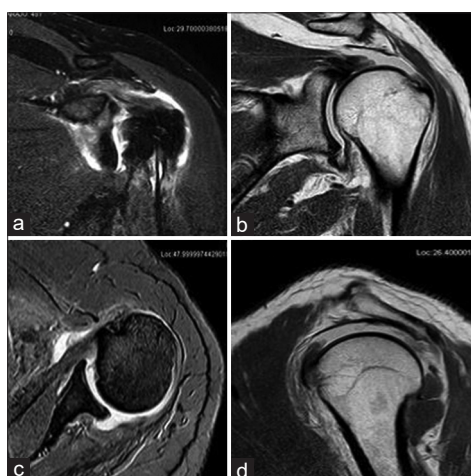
MRI images in coronal (a and b), axial (c), and sagittal (d), show a full-thickness tear of the supraspinatus
